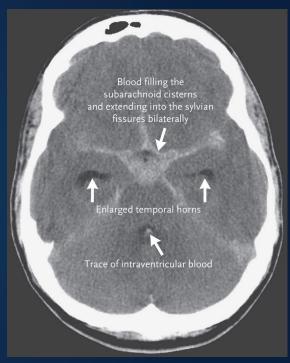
CT scan showing subarachnoid hemorrhage. Adapted from Subarachnoid Hemorrhage, by Lawton and Vates, 2017. Retrieved from https://www.nejm.org/doi/full/10.1056/NEJMcp1605827.
